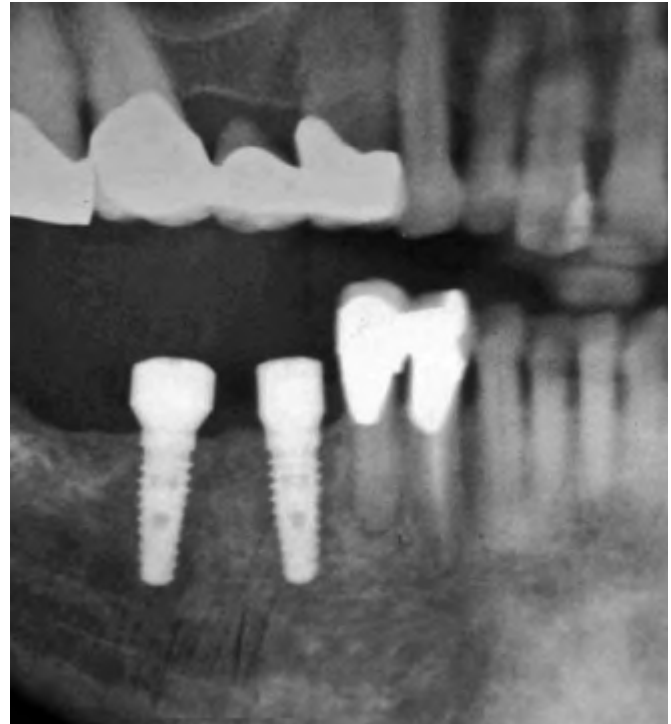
This quadrant section of a panoramic radiograph was taken immediately post implant placement. The implants were placed, with the benefit of CT treatment planning, without violating the inferior alveolar canal and/or the mental nerve.
